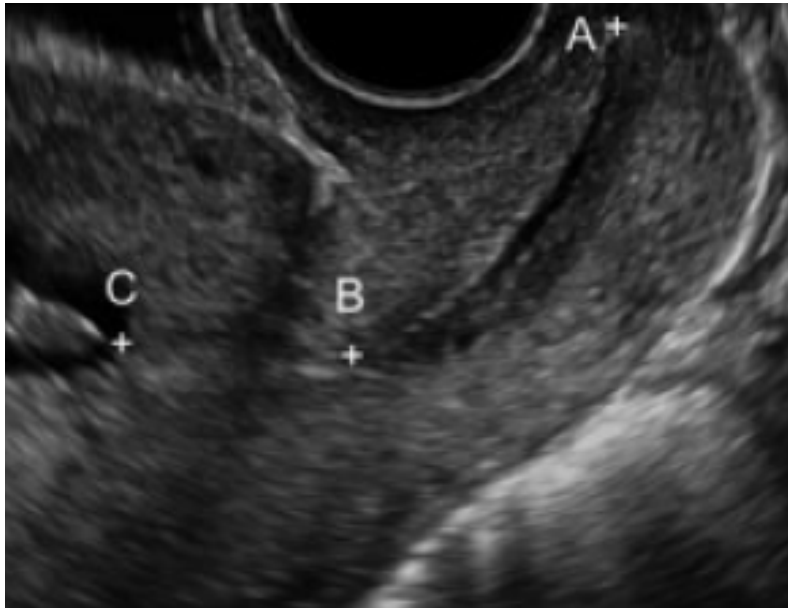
Ultrasound image of the cervix obtained with vaginal ultrasound. A, outer cervical os; B, inner cervical os; C, the virtual inner cervical os created by the opposition of the anterior and posterior isthmus. The following measurements are taken: A-B (length of the closed cervical canal); B-C (length of the isthmus); A-C. A fourth measurement result is obtained by adding (A-B) and (B-C).
